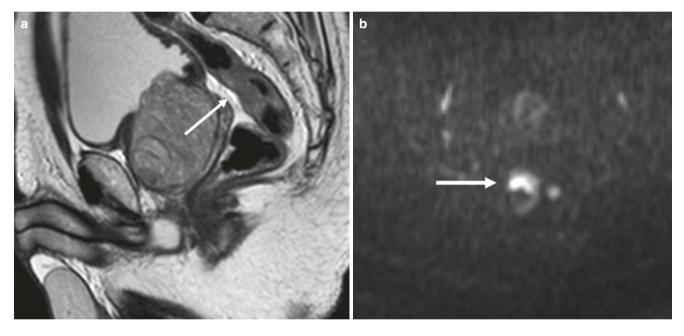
MRI of T1/2 tumor with with diffusion-weighted imaging. (a) Sagittal T2 image shows a muscle contained (T1-T2 tumor) focal rectal cancer (white arrow). (b) with positive bright signal on axial diffusion imaging (white arrow). (Courtesy of Vincent Pelsser, MD)
